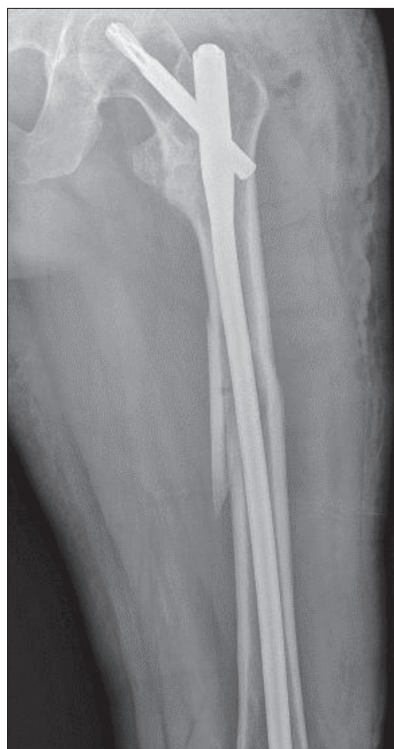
Radiography of the left hip joint and femur on admission; peri-implant femoral fracture at the level of the tip of the nail [source: PACS Bežanijska Kosa UHMC]
